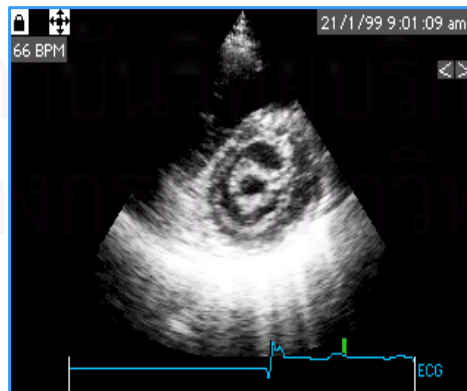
Two-dimensional echocardiography demonstrated the short axis at the mitral valve level. Mitral valve area can be obtained by planimetry of the orifice area.
